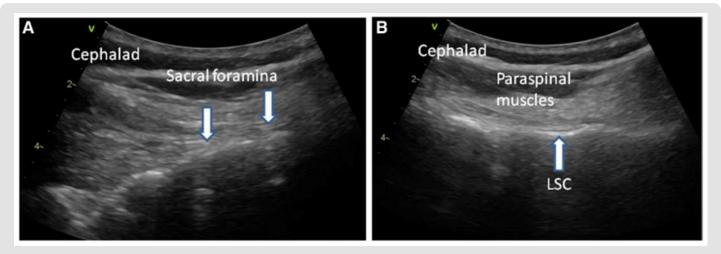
Sonographic view of cryoprobe insertion site.
